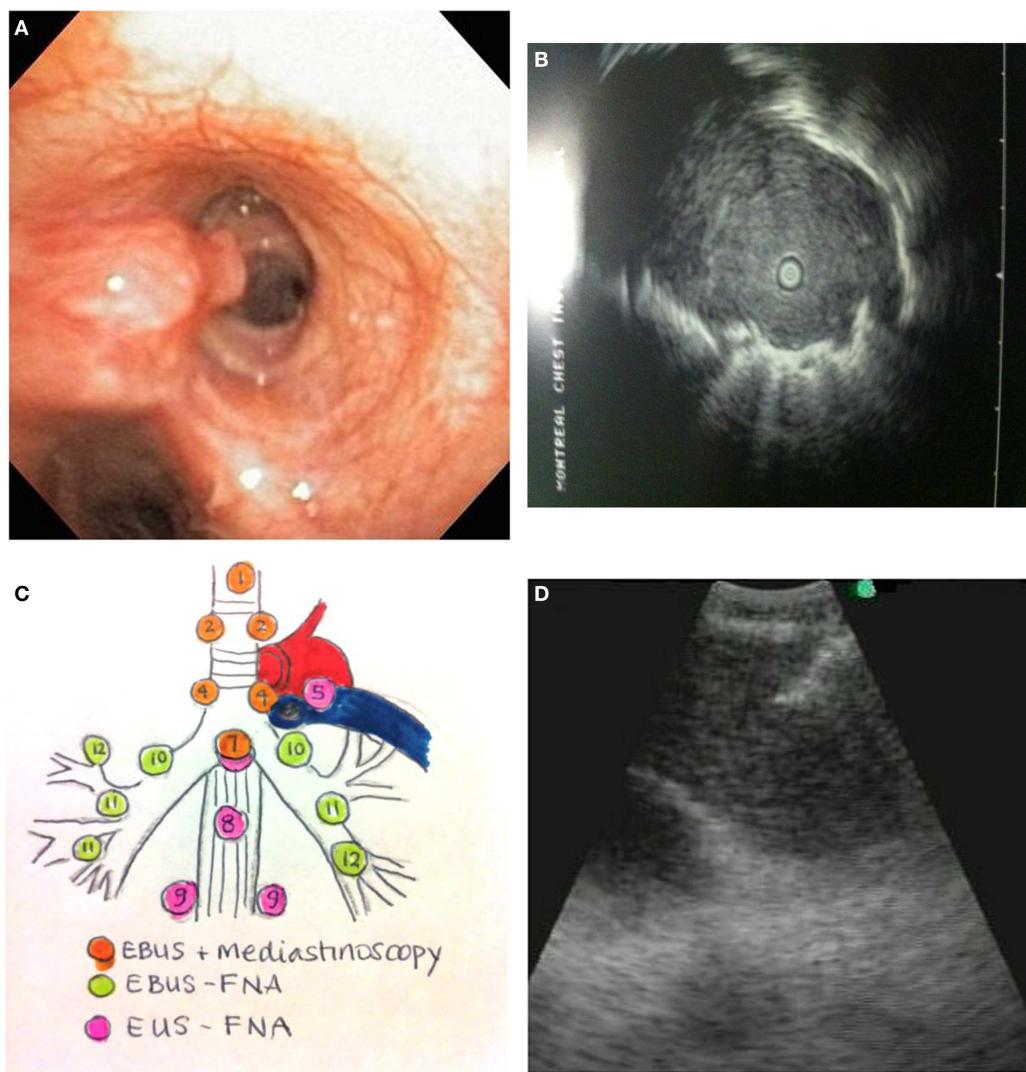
(A) Endobronchial tumor visible in an airway. (B) Ultrasound image of a peripheral lung cancer as visualized by radial EBUS-GS. The clear central area is the ultrasound probe in the airway. The surrounding isoechoic shadow represents a tumor. The hyperechoic line surrounding the tumor is an ultrasound phenomenon produced by the sudden change in tissue density
